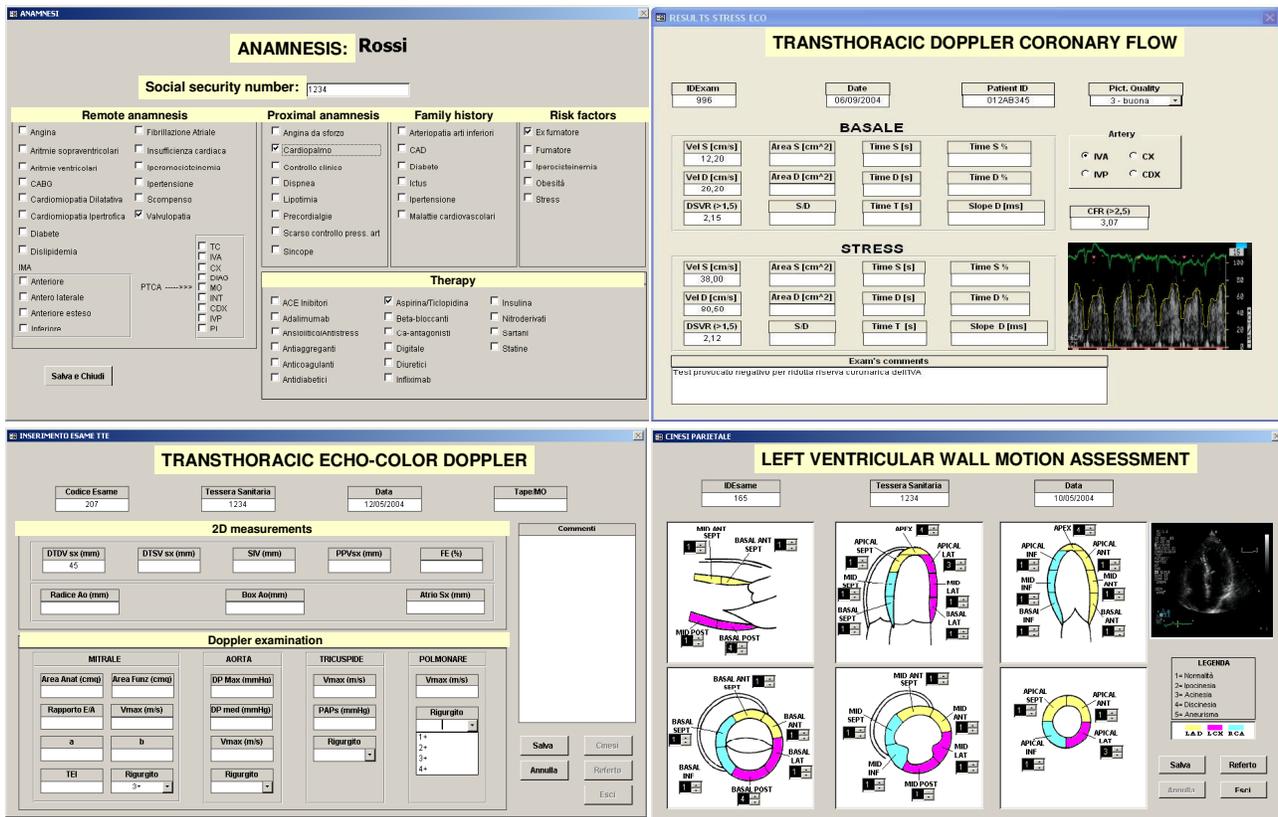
Specific masks for data-entry: general anamnesis (top-left), coronary flow reserve examination (top, right), transthoracic 2D echo-color Doppler (bottom, left), left ventricular regional wall motion assessment (bottom, left)
